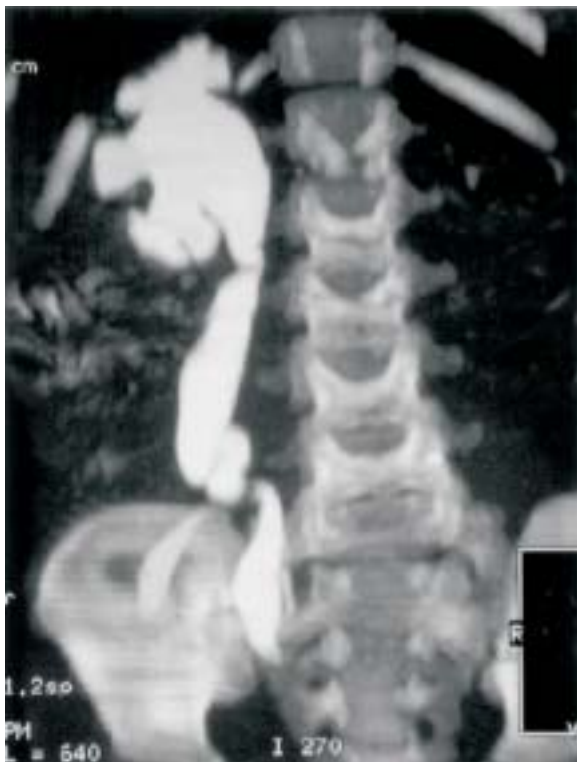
A 5-year-old boy with a history of congenital heart disease who presented with symptoms of recurrent urinary tract infection. CT urography shows agenesis of the left kidney. Marked right hydronephrosis and hydroureter is also noted. VATER syndrome of this boy was diagnosed.
